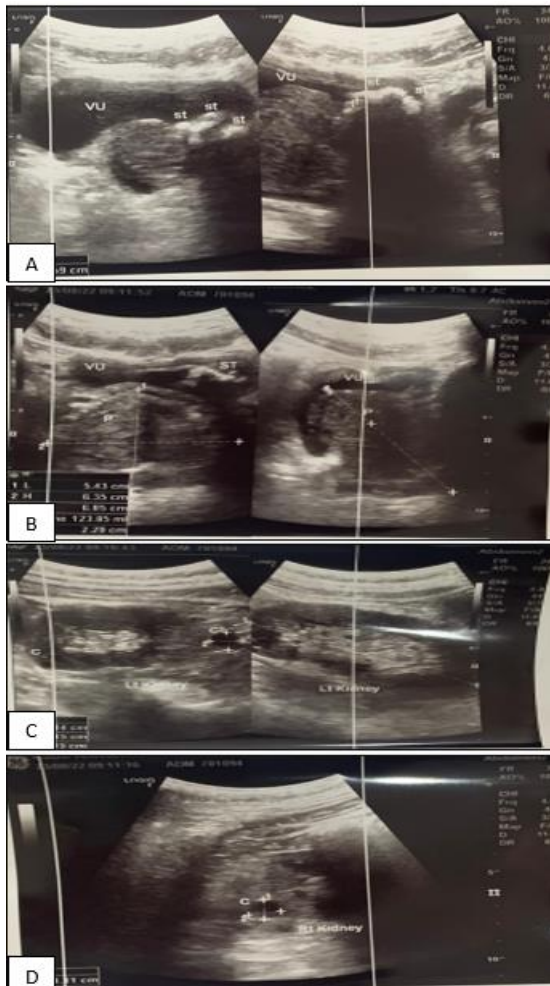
(A-D): Ultrasound of the patient.
